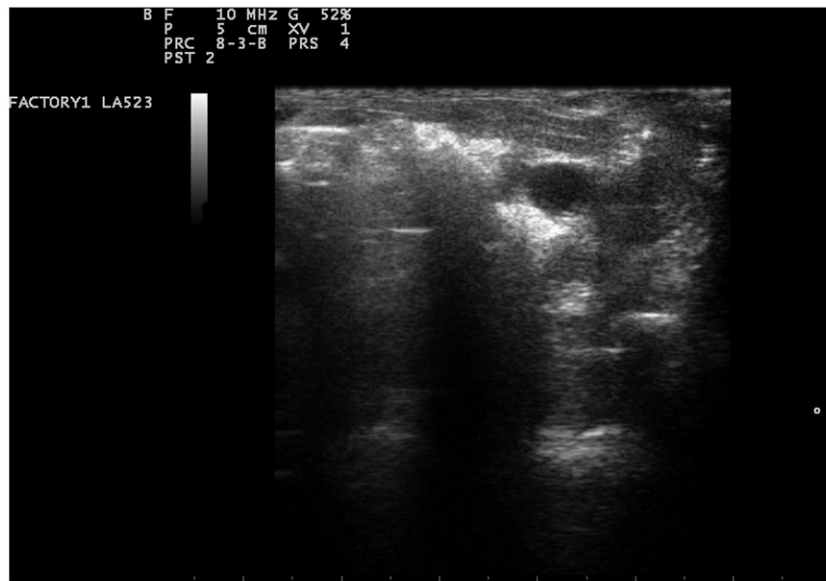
Ultrasonographic examination of the uterine body and horns (dorsal recumbency, 10 MHz multi-frequency linear probe array): uterine body and horns dilated (maximum diameter 9 mm) containing heterogenic fluid presenting flocculation. Thickened (maximum thickness 4 mm compared to 2 mm being the upper limit of reference range) and hyperechoic endometrium is visible.
